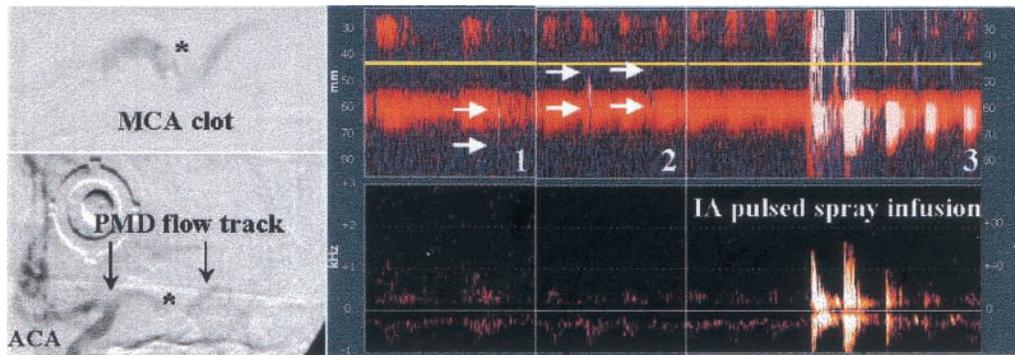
Branch embolization flow signature. An 80-year-old man with a total National Institutes of Health Stroke Scale score of 15 had an elongated clot in the M1 middle cerebral artery (MCA) stem (left panel). An asterisk shows the depth of a single-gate transcranial Doppler (TCD) spectral monitoring of the worst residual flow signals at the site of maximum occlusion (gate = 9 mm). Power motion mode Doppler (PMD) shows a proximal MCA flow and embolic signals traveling in the opposite direction to the anterior cerebral artery (ACA) (60- to 72-mm depths; frame 1) and perforators (48- to 60-mm depths; frame 2). When an intra-arterial pulsed-spray infusion was initiated (frame 3), multiple embolic signals were seen, with PMD displaying more signals than a single-gate spectral TCD. Also, spectral overload from the pulsed-spray injections creates saturation artifacts on PMD, decreasing its appearance (vertical length and brightness) after the first 2 infusion cycles. IA = intra-arterial.
